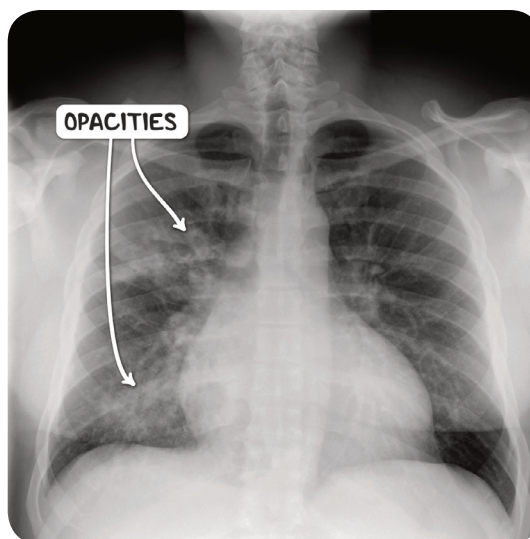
A plain chest radiograph demonstrating patchy peri-bronchial shadowing in an individual with bronchopneumonia.
